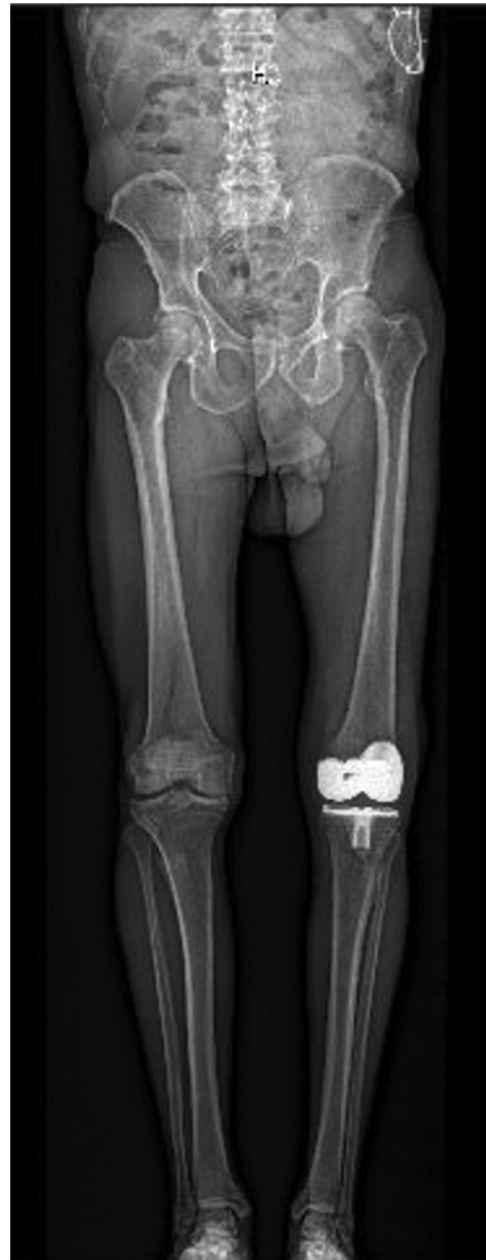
Anteroposterior alignment radiograph.
